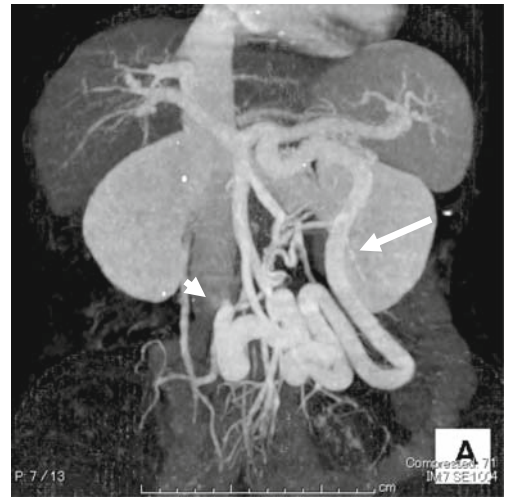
Maximum intensity projection (MIP) computed tomography (CT) portography. The diameter of the inferior mesenteric vein (IMV) shunt (*arrow*) is larger than those of the intrahepatic portal branches and the superior mesenteric vein (SMV). The efferent orifice of the tortuous IMV to the inferior vena cava (IVC) is clearly visualized (*arrowhead*)
